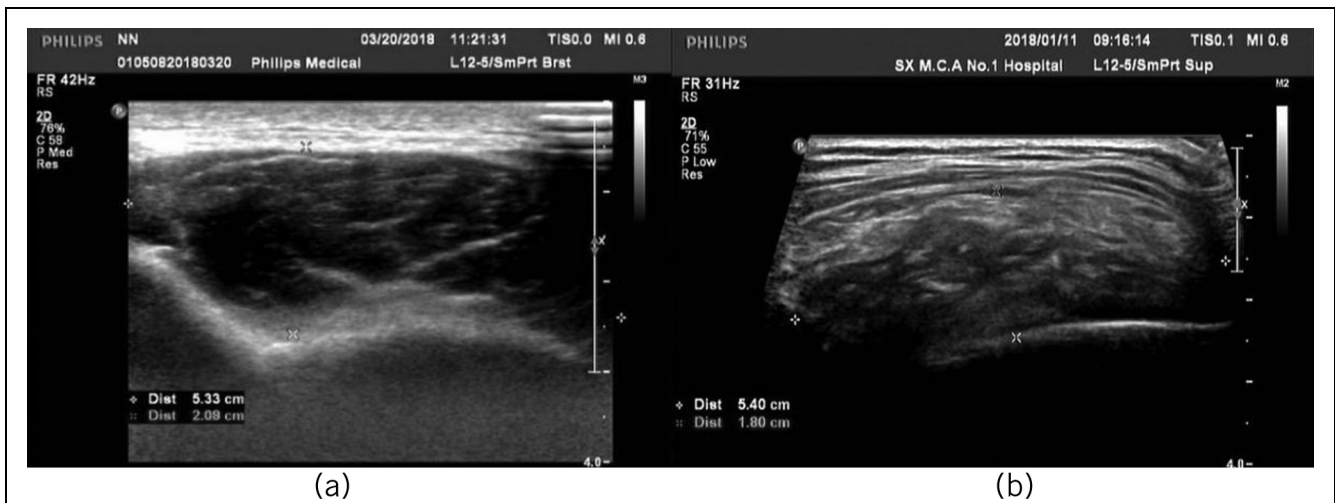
Ultrasound showing the characteristic findings.
